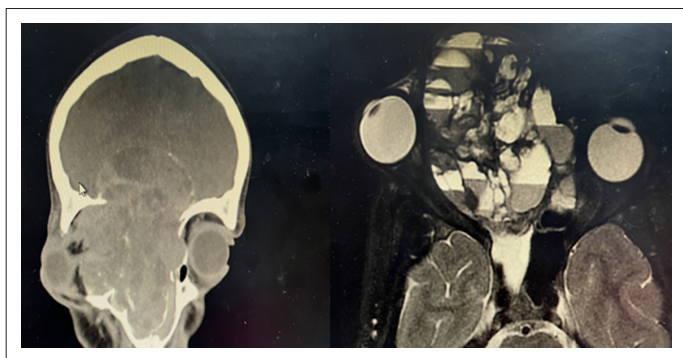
Coronal and axial magnetic resonance images of the brain and orbits demonstrate a multiloculated cystic lesion of osseous origin, filling the frontal, ethmoidal, right maxillary sinus, and right nasal cavity. The lesion contains fluid–fluid levels, and extends into the intracranial extradural space, compressing the adjacent brain parenchyma.
